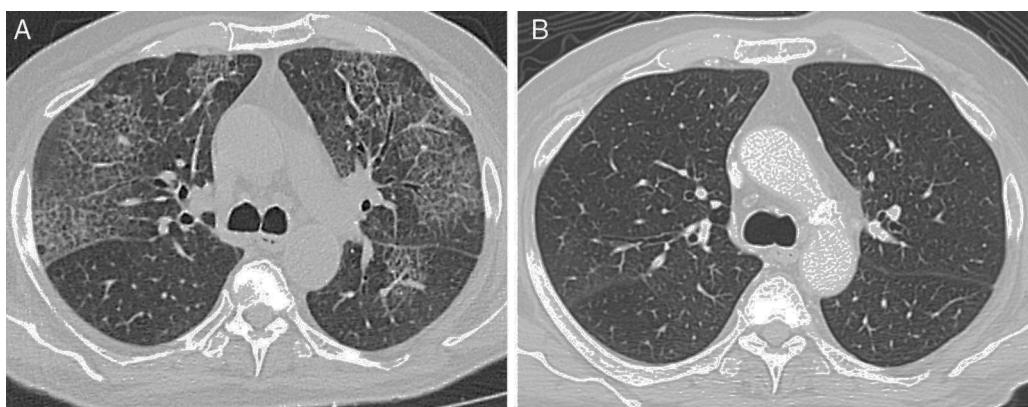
(A) Chest high-resolution computed tomography showing bilateral ground glass opacities and interlobular septal thickening. (B) Chest high-resolution computed tomography after corticosteroid treatment, showing resolution of the pulmonary lesions.
